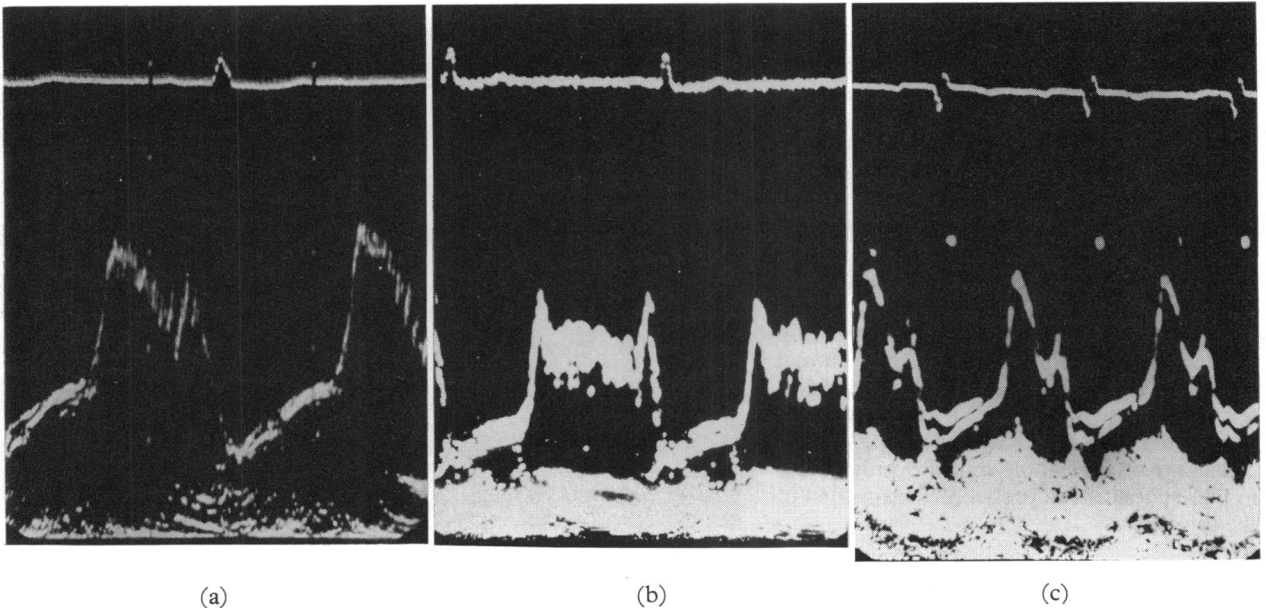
Echocardiograms from patients with lone aortic regurgitation. (a) Chronic lone aortic regurgitation of rheumatic origin. Soft Austin Flint murmur. Left ventricular end-diastolic pressure 15 mm. Hg. The echocardiogram shows a diastolic closure rate of 60 mm./sec., a thin valve with fast oscillations and normal timing of mitral valve closure. All murmurs disappeared and the mitral echocardiogram became normal postoperatively. (b) Syphilitic aortic regurgitation. No heart failure. Austin Flint murmur. Mitral echocardiogram shows wide amplitude, fast oscillations. Normal reopening after atrial contraction and normal timing of systolic closure denotes a normal left ventricular end-diastolic pressure (confirmed in Fig. 6). (c) Chronic severe aortic regurgitation after repair of ventricular septal defect. There was no Austin Flint murmur. The left ventricular end-diastolic pressure was 17 mm. Hg. The mitral echocardiogram shows no diastolic oscillations, diastolic closure rate over 100 mm./sec., slightly premature mitral valve closure after normal reopening after atrial contraction associated with a prolonged PR interval (0.24 sec.).
